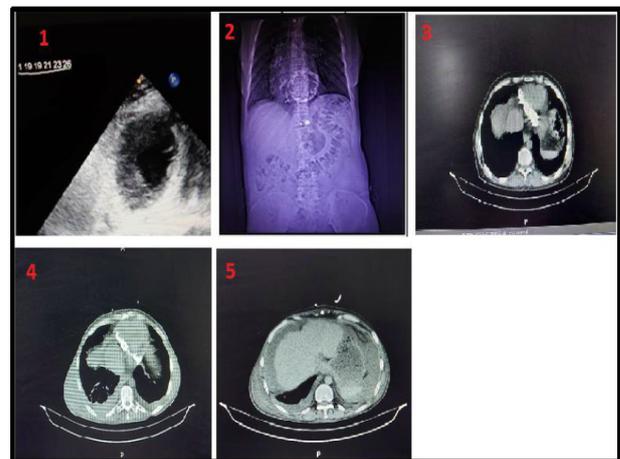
Echocardiography of the patient showing pericardial calcification, 2. Chest radiograph of the patient in PA view showing pericardial calcification, 3. CT scan of the patient; Mediastinal view showing pericardial calcification, 4. CT scan of the patient's chest in the Mediastinal view showing bilateral pleural effusion and pericardial calcification, 5. CT scan of the patient's chest in the Mediastinal view in the end cuts showing pleural effusion of the right lung and abdominal ascites.
